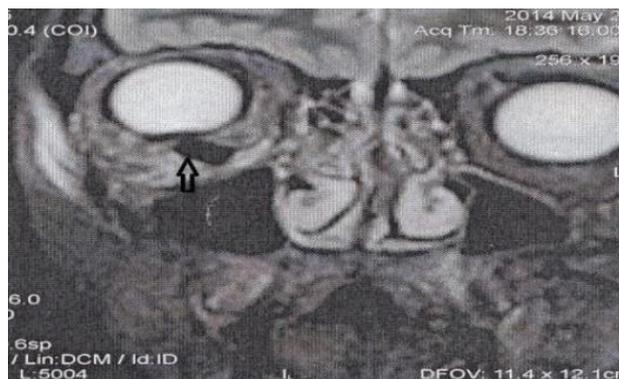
Coronal T1WI MRI showing the intraorbital foreign body (black arrow) (Turliuc *et al.*, 2015a).
